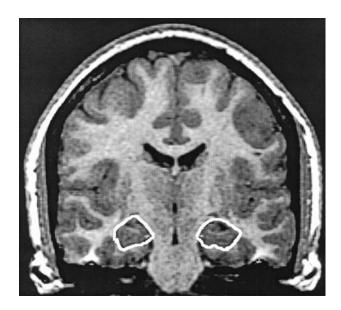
Example of a structural MRI, with the hippocampus traced bilaterally in a coronal slice. In the region-ofinterest analysis, an anatomical structure is usually traced in several slices, and the volume is derived from the sum of the areas multiplied by the slice thickness. For the hippocampus, semiautomated procedures are utilized to include in the analysis only the pixels identified as gray matter.
